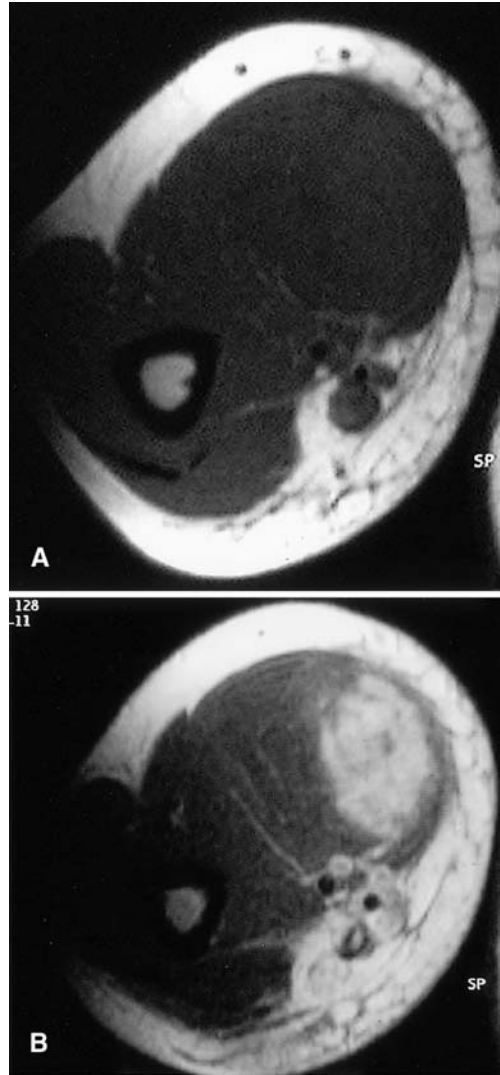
A T1-weighted axial MR image (644/12) obtained at the same level, showing a muscle-isointense lesion. B Note the homogeneous enhancement after intravenous gadolinium
